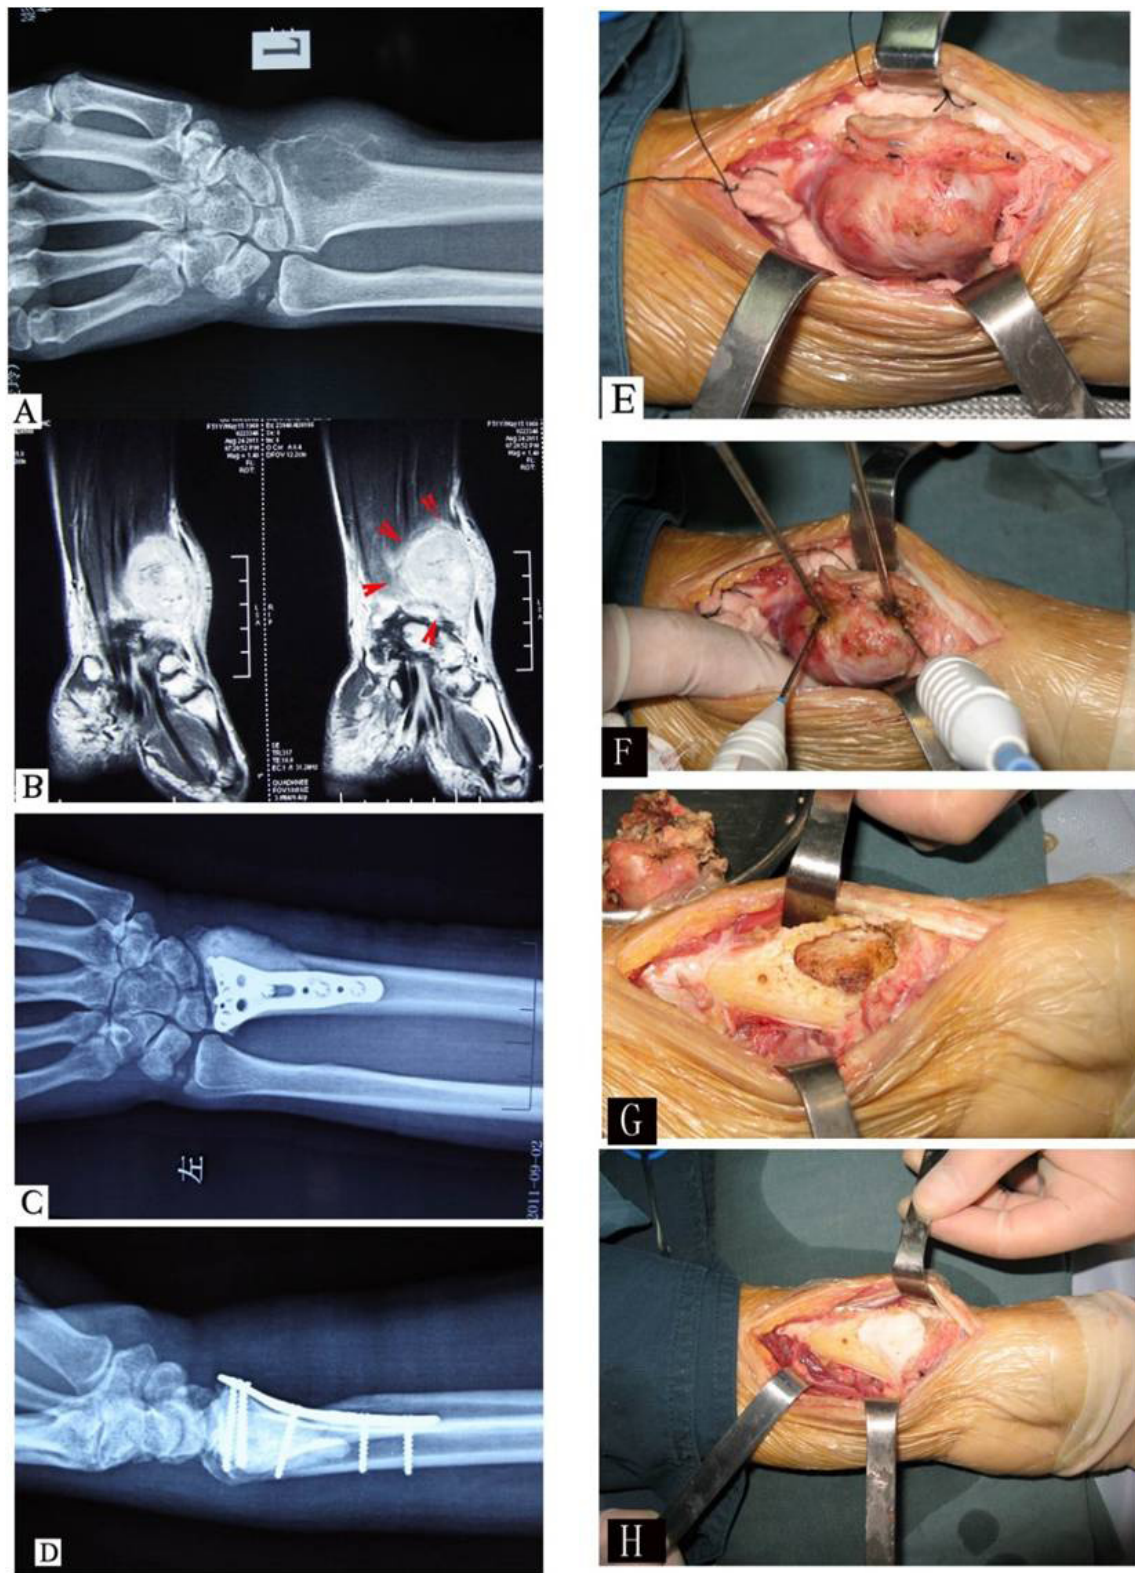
Procedure of MWA for a GCT of the distal radius (X-ray film taken at 8/31/2011).
